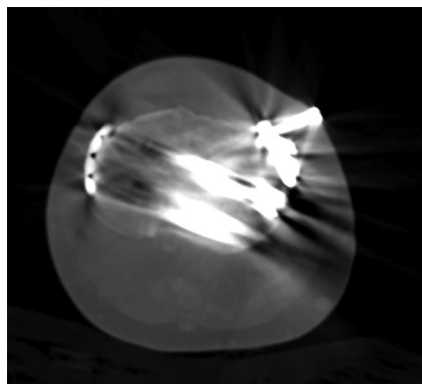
Axial computed tomography (CT) scan demonstrating a sinus tract to the plate and screw construct of the proximal tibia.
